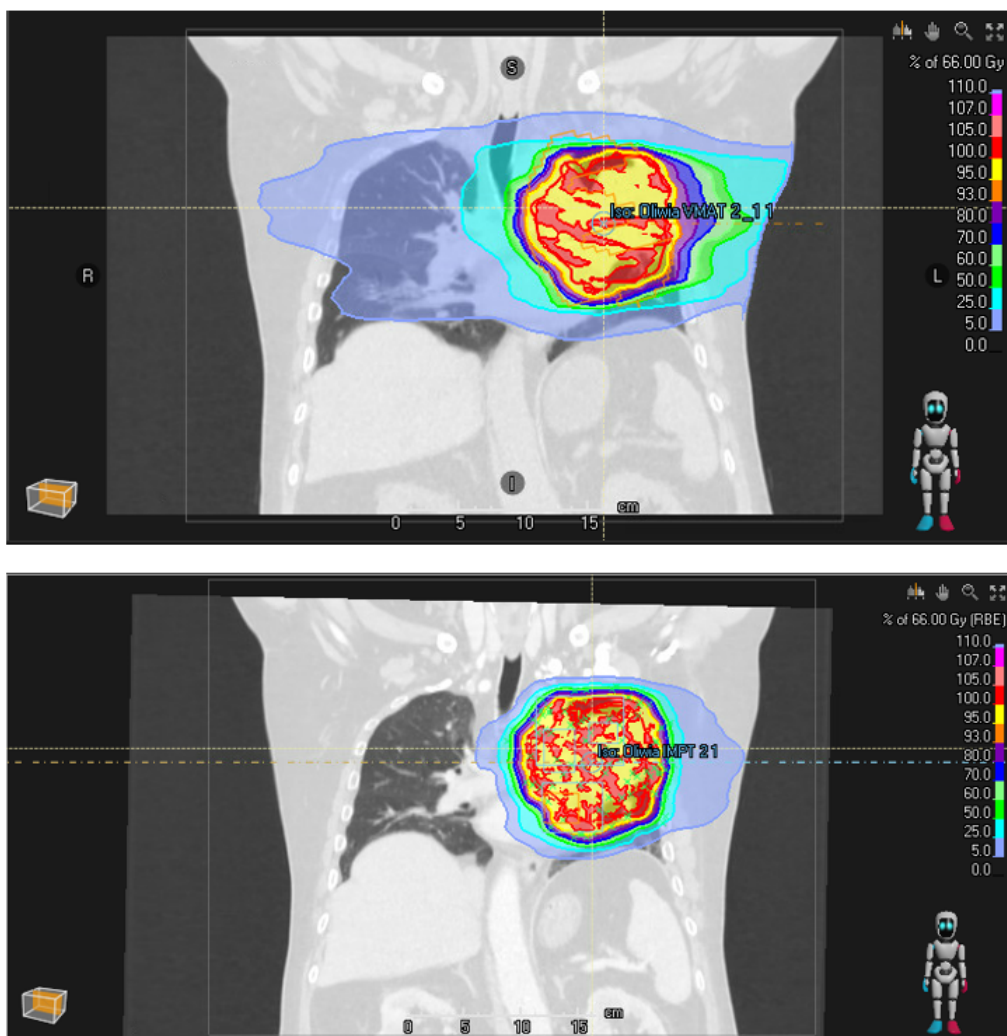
A single CT slice for patient 2, an example showing how the IMPT delivers dose more precisely than VMAT, saving dose to healthy lung tissue (VMAT above and IMPT below).
